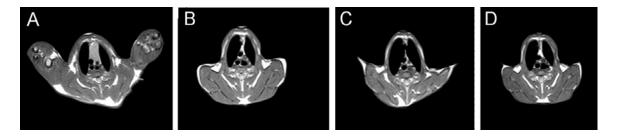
MR images of an irradiated subject, immediately prior to irradiation (A), and at 7 days (B), 14 days (C), and 21 days (D) post-irradiation (PI). All images are from approximately the same level of the cranial thorax. Note the progressive decrease in thymic size over the two weeks following radiation, followed by a mild increase in size, interpreted as thymic rebound or regeneration, at three weeks PI.
